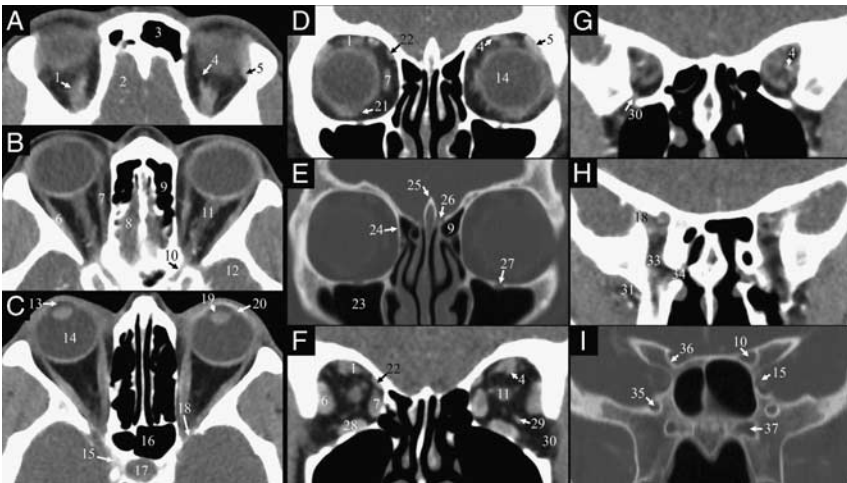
A–C, Axial contrast-enhanced CT images of the orbits progressing from superior to inferior. A, Image through the superior orbits demonstrates the levator palpebrae and superior rectus muscles (1) which are often not clearly delineated from each other, the frontal lobe (2), frontal sinus (3), enhancing superior ophthalmic vein (4), and enhancing lacrimal gland (5). B, Image through the mid orbits demonstrates the enhancing lateral rectus muscle (6), enhancing medial rectus muscle (7), olfactory bulb (8), ethmoid air cells (9), optic canal (10), intraorbital optic nerve (11), and temporal lobe (12). C, Image through a more inferior portion of the mid orbits shows the anterior segment of the eye (13), vitreous body (14), enhancing cavernous sinus (15), sphenoid sinus (16), pituitary fossa (17), superior orbital fissure (18), lens (19), and ciliary body (20). D–I, Coronal contrast-enhanced CT images of the orbits progressing from anterior to posterior. D, Image through the anterior orbits on soft tissue window demonstrates the enhancing extraocular muscles including the inferior oblique (21) and superior oblique (22). E, Image through the anterior orbits on bone window demonstrates the maxillary sinus (23), lamina papyracea (24), crista galli (25), cribriform plate (26), and infraorbital canal (27). F, Image through the mid orbits shows the enhancing extraocular muscles including the inferior rectus (28), as well as the enhancing inferior ophthalmic vein (29) and inferior orbital fissure (30). G, Image through the anterior orbital apex shows the converging extraocular muscles with a portion of the inferior orbital fissure (30) and the conspicuously enhancing superior ophthalmic vein (4). H, Image at the level of the posterior orbital apex shows the masticator space (31), superior orbital fissure (18), pterygopalatine fossa (33), and sphenopalatine foramen (34). I, Image through the optic canals (10) shows the foramen rotundum (35), optic strut forming the floor of the optic canal (36), cavernous sinus (15), and Vidian canal (37). CT indicates computed tomography.
